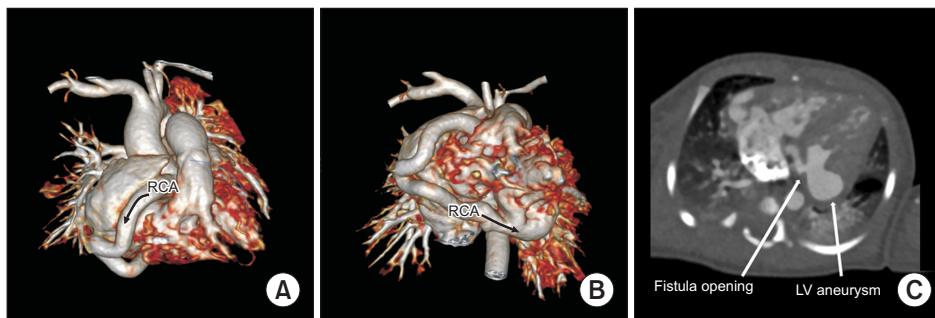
Preoperative heart computed tomography. (A) A three-dimensional (3D) reconstruction shows the dilated right coronary artery (RCA) with a proximal diameter of 6.1 mm (arrow). (B) A 3D reconstruction shows the distal RCA (arrow) terminating into the base of the left ventricle (LV). (C) In the axial plane, the LV aneurysm measured 13.3×12.5 mm and the RCA fistula opened immediately right and superior to the neck of the LV aneurysm.
